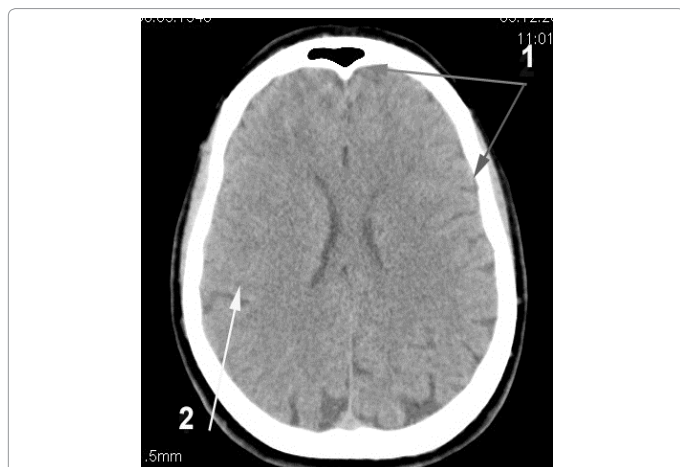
Same patient H.: CT of the brain. 6 Years after the Intervention: 1) the structure of the right hemisphere cerebral tissue is restored. 2) no signs of residual effects of the post-ischemic cyst.
